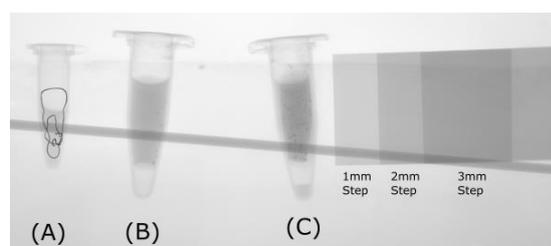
2D X-ray Microtomography of hydrogel samples
